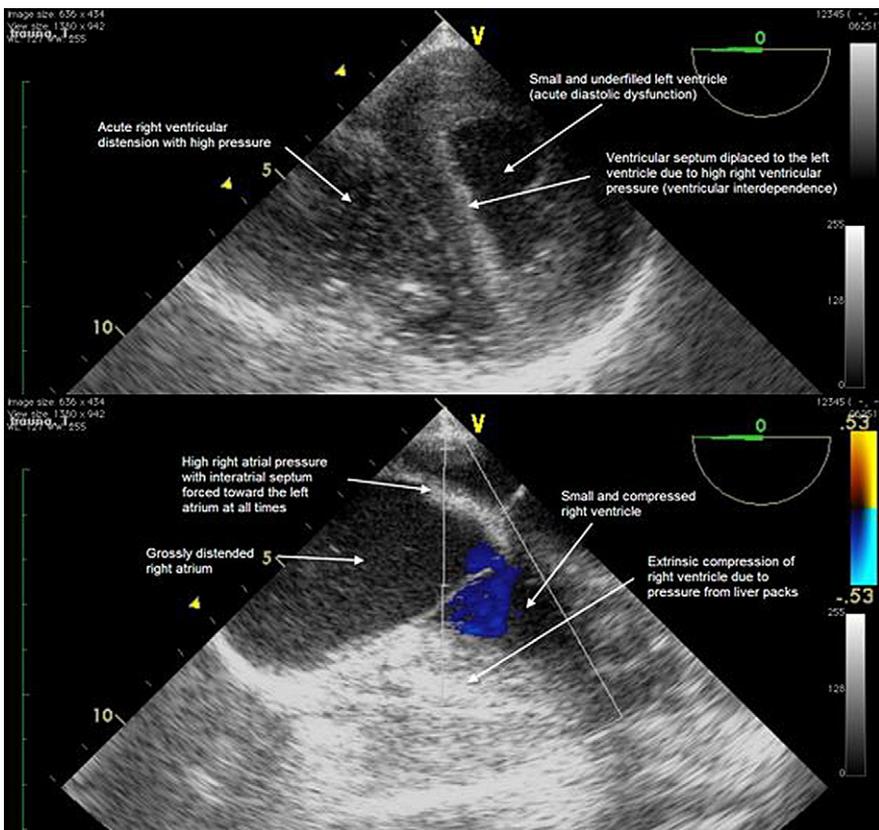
Transoesophageal echocardiography images of right ventricular compression caused by surgical packs placed around the liver. The compression has also “squashed” the left ventricle, inducing acute left ventricular diastolic dysfunction.
